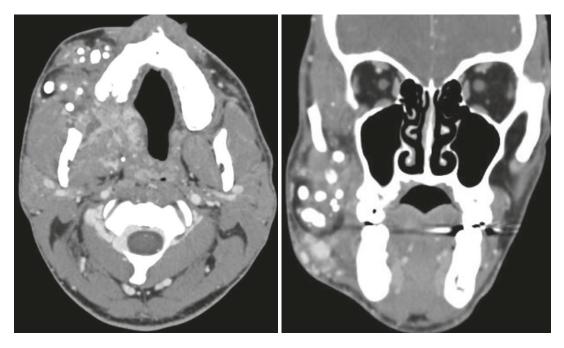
Contrast-enhanced axial and coronal CT images show soft tissue mass with serpiginous enhancement and numerus phleboliths involving multiple compartments of the right face, suggestive of low flow lympho-venous malformation
